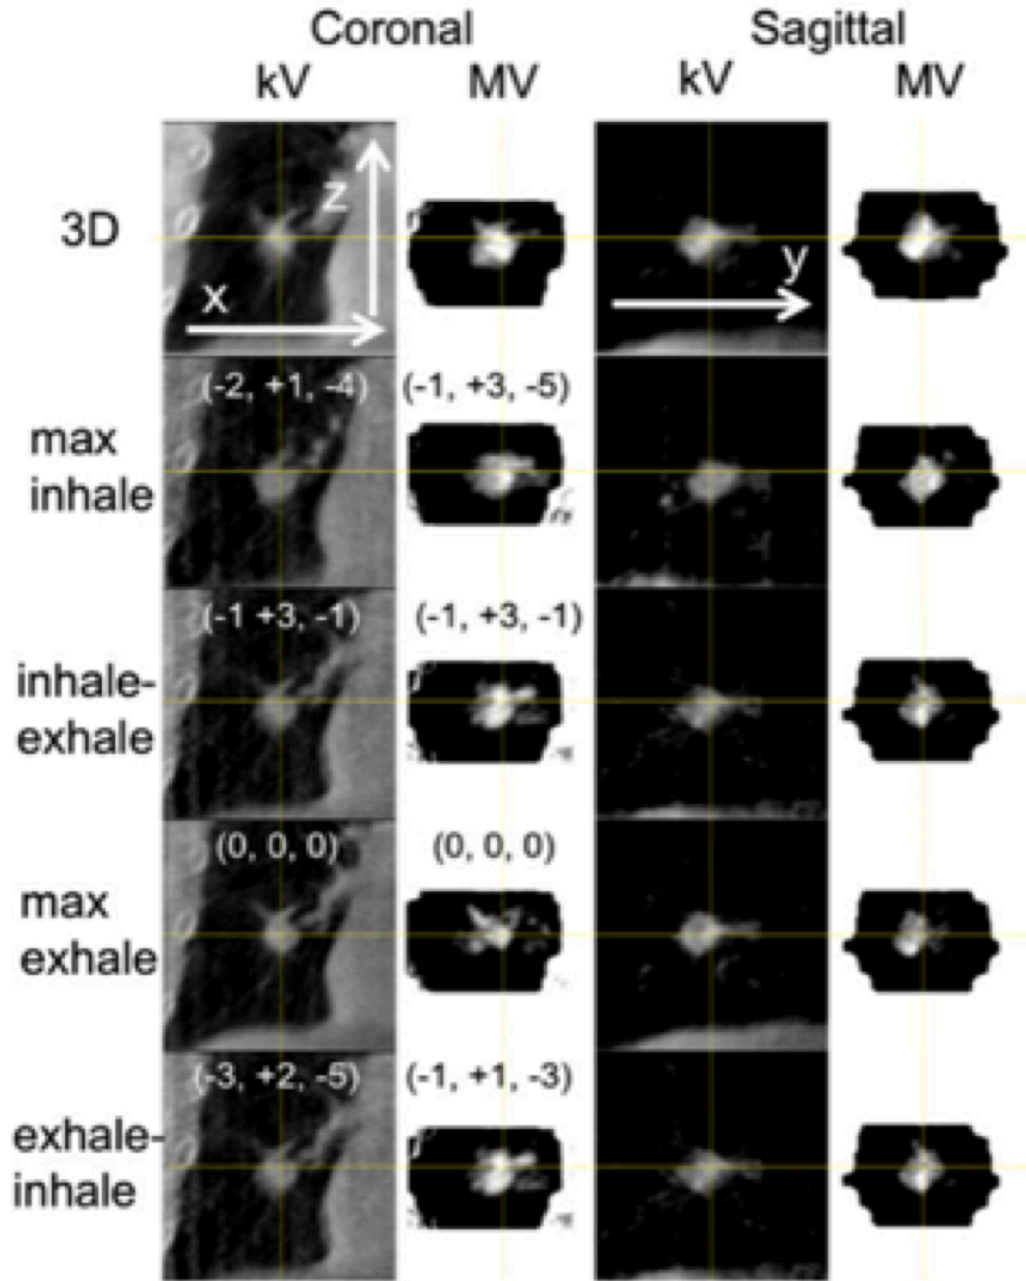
4D VMAT-CT reconstruction result for 4D lung treatment compared to in-treatment 4D CBCT (Kida *et al.*, 2011).
